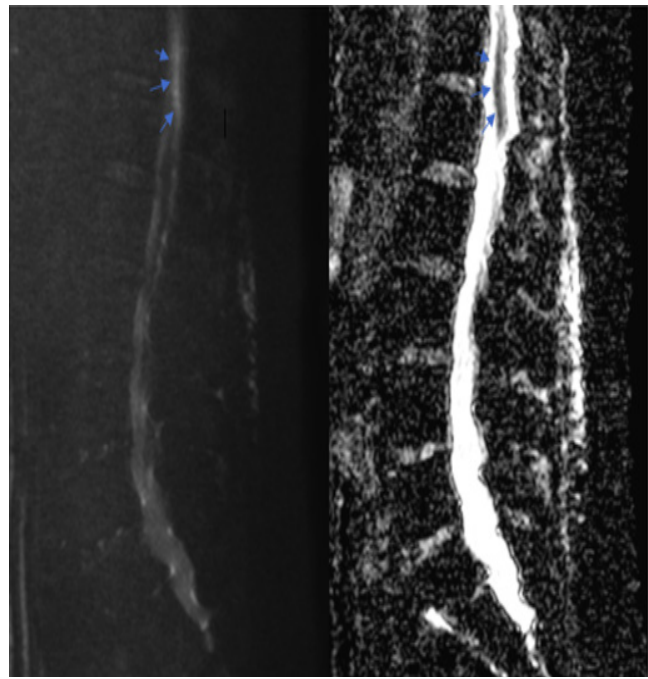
Lumbosacral magnetic resonance imaging: sagittal DWI and ADC sequences showing hyperintensity in the anterior portion of the spinal cord in DWI correlating with hypointensity in ADC (blue arrows) at segments T12 and L5, evidencing spinal cord infarction.
